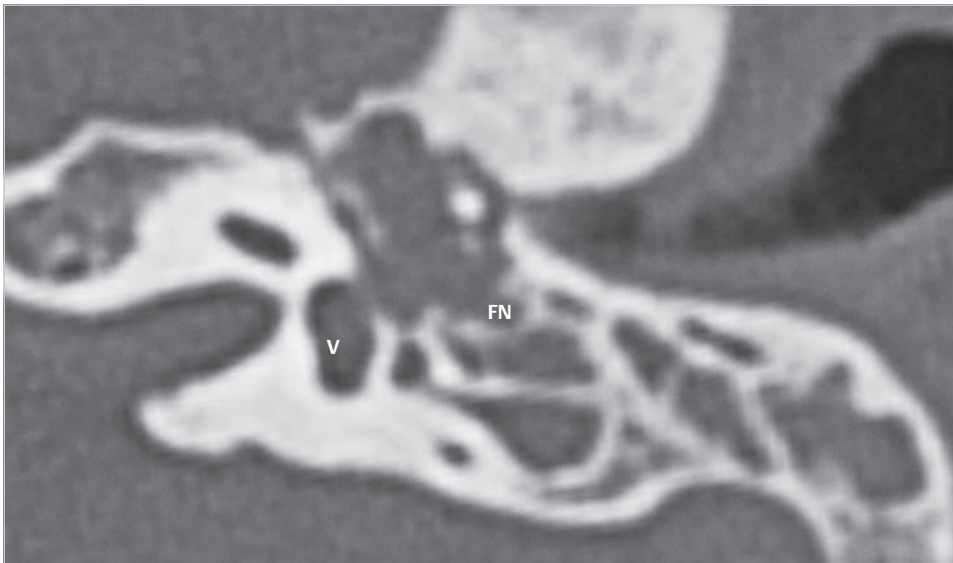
A case of 12-year-old child with epitympanic cholesteatoma is shown. The axial CT shows soft tissue density filling the middle ear. Bone density of both the long process of the incus and the superstructure of the stapes seem to be reduced. Preoperative otoscopy and hearing test show ventilated tympanic cavity with normal hearing. Note the large cells located posteriorly to the facial nerve. FN, facial nerve; V, vestibule.
